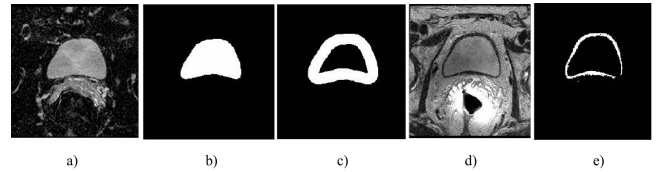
a) Bladder on DWI image. b) Segmented bladder on DWI. c) Stripe around bladder wall on DWI d) Bladder on T2w image. e) Segmented bladder wall on T2w image.
